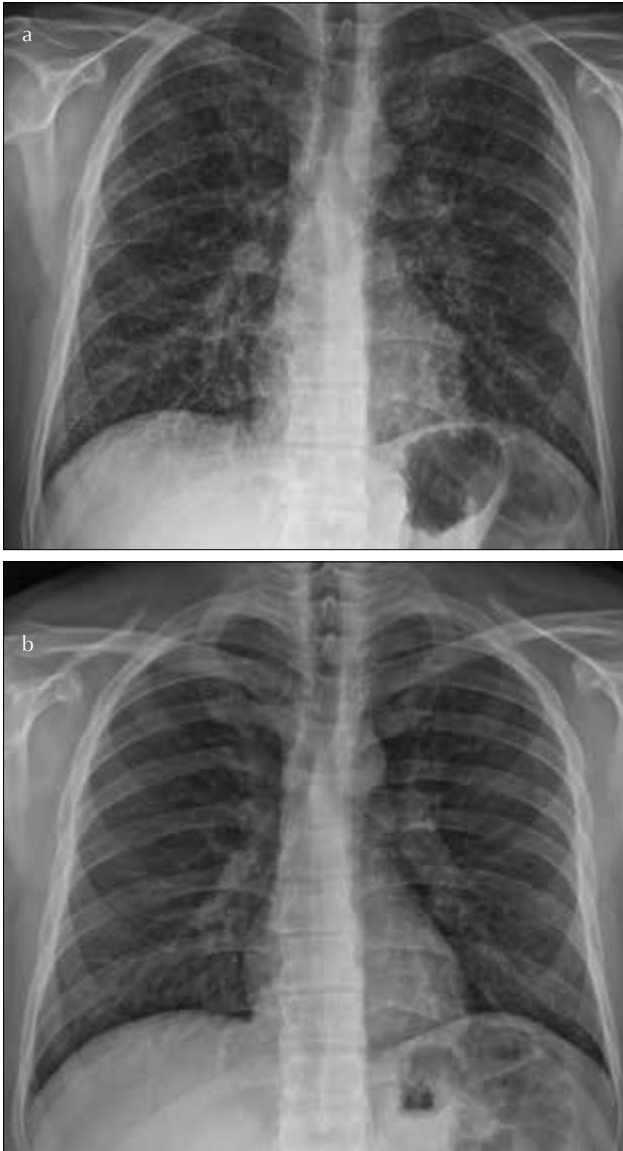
a, b. Chest x-ray at admission, bilateral generalized reticulonodular infiltration (a). Normal chest X-ray: 1 month before admission (b)
